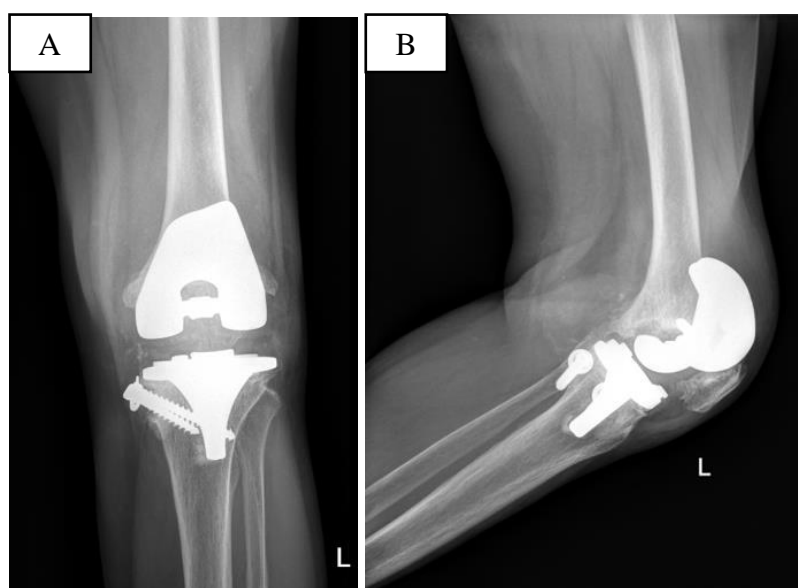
Plain radiograph patients left knee AP (a) and Lateral (b) view taken on admission date.
